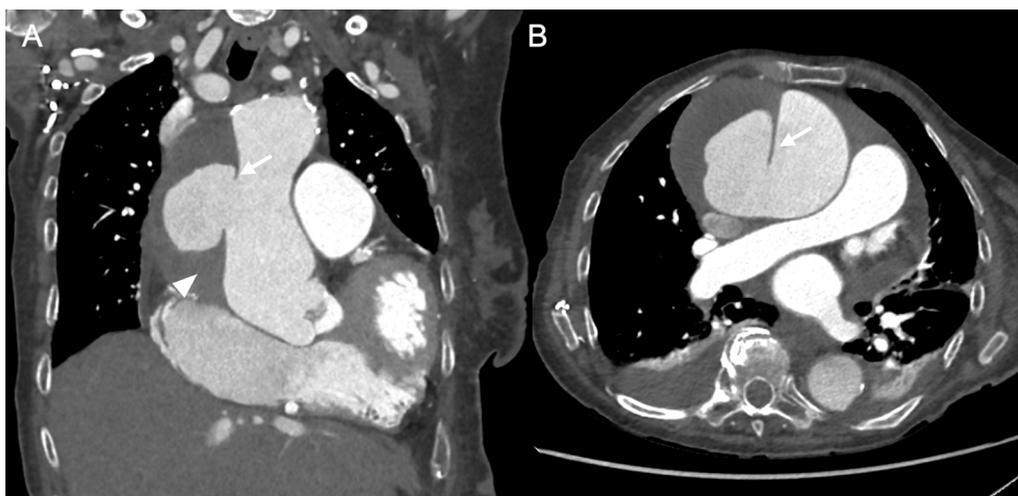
94-year-old woman admitted for congestive heart failure who, that morning, had developed chest and abdominal pain with paraesthesia in both lower limbs. Coronal (A) and axial (B) reconstructions of chest CT angiography to study pulmonary arteries for suspected pulmonary thromboembolism show a large pseudoaneurysm in the ascending thoracic aorta (arrow) and an adjacent mediastinal haematoma (arrowhead) containing the pseudoaneurysm.
